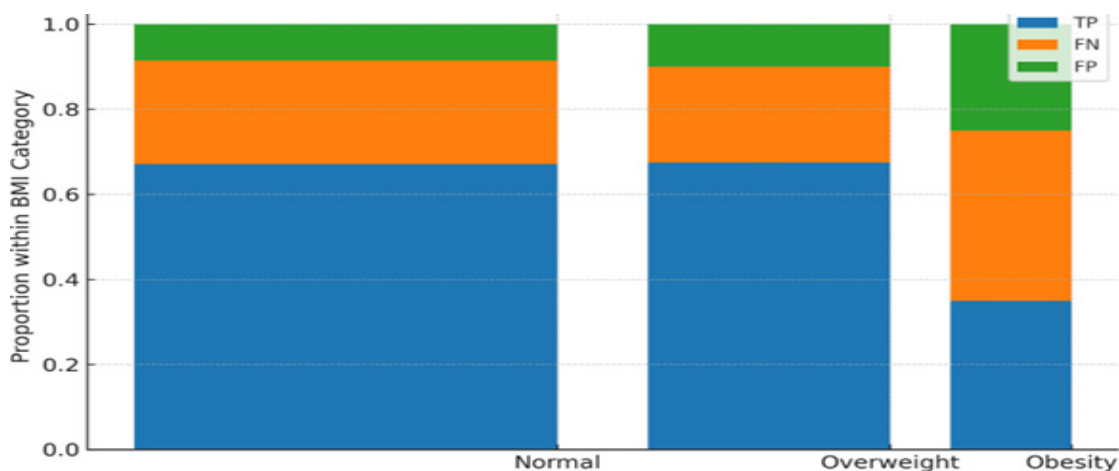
Mosaic (Marimekko) plot of ultrasound outcomes by BMI category
